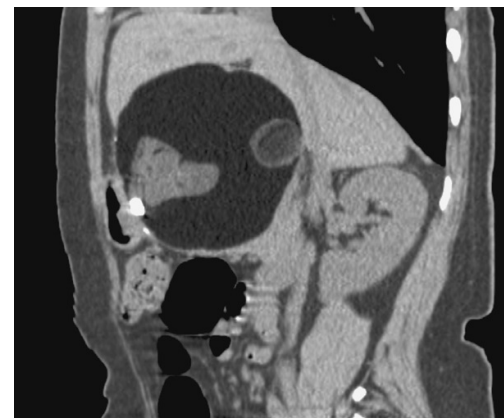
Horizontal abdominal CT scan showed a cystic-solid mass in the lesser omentum.
